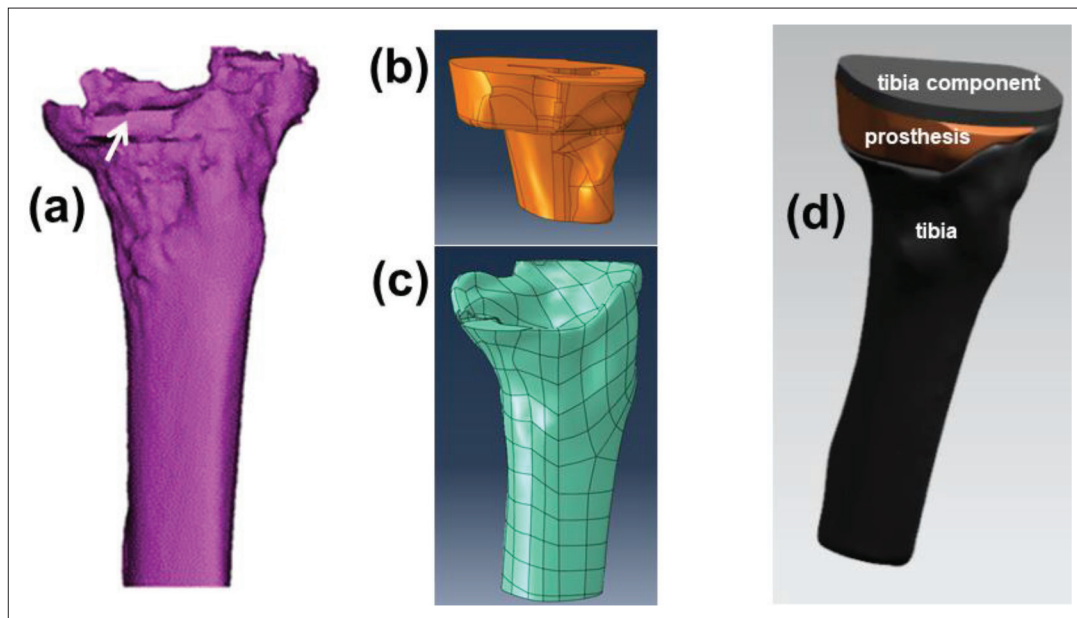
3D models for the constructed tibia and prosthesis. (a) The original tibia constructed from the CT data; the arrow indicates the defect site. (b) The designed prosthesis. (c) The polished tibia. (d) The assembly.
